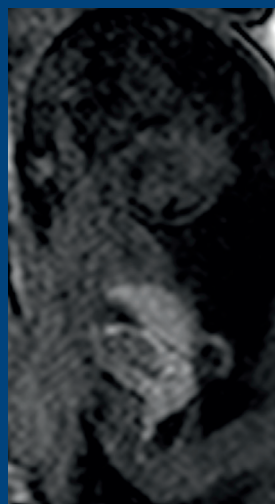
T-1 weighted MRI image.
